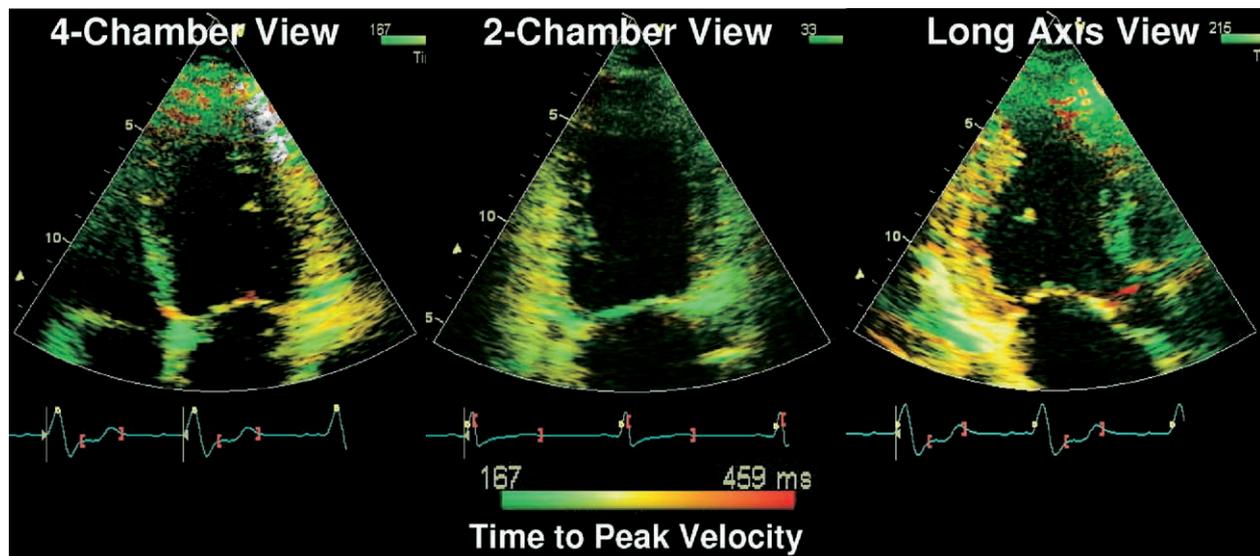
Tissue Doppler study from 3 standard apical views demonstrating color coding of time to peak velocity data from patient with dyssynchrony who responded to resynchronization therapy. Lateral wall (4-chamber view) and posterior wall (apical long-axis views) are color-coded *yellow-orange*, indicating delay in time to peak velocity.
